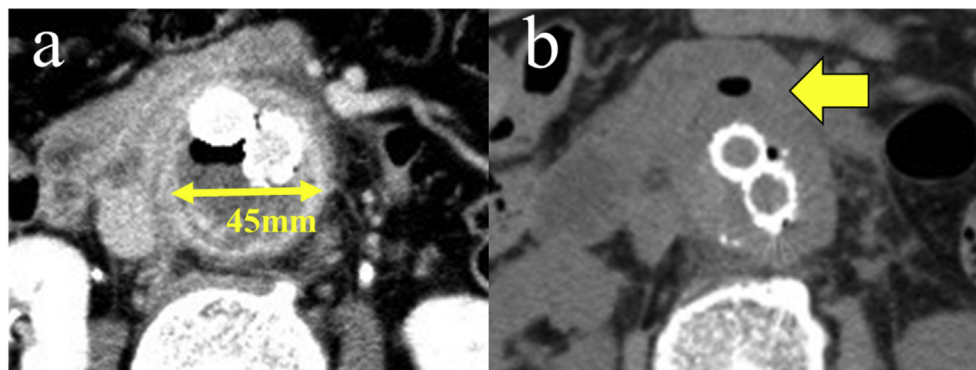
Delayed enhanced CT at five years and eight months on re-admission (A, on re-admission). Two days after readmission (B), ventral protrusion of the aneurysm sac was confirmed.
